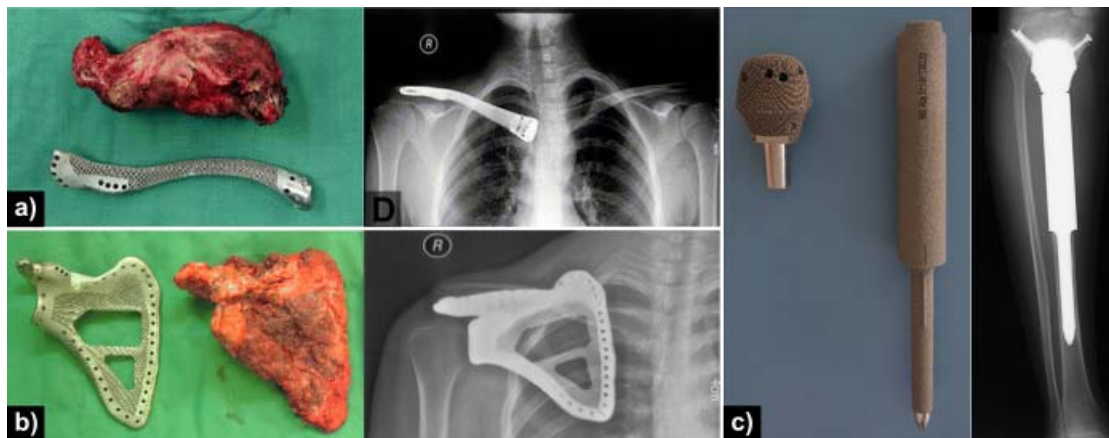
Examples of AM patient specific implants used for reconstruction of resected bone tumours and follow-up x-ray films showing placement, specifically a) clavicle, b) scapula, and c) uncemented proximal tibial reconstruction^{52,53}.
